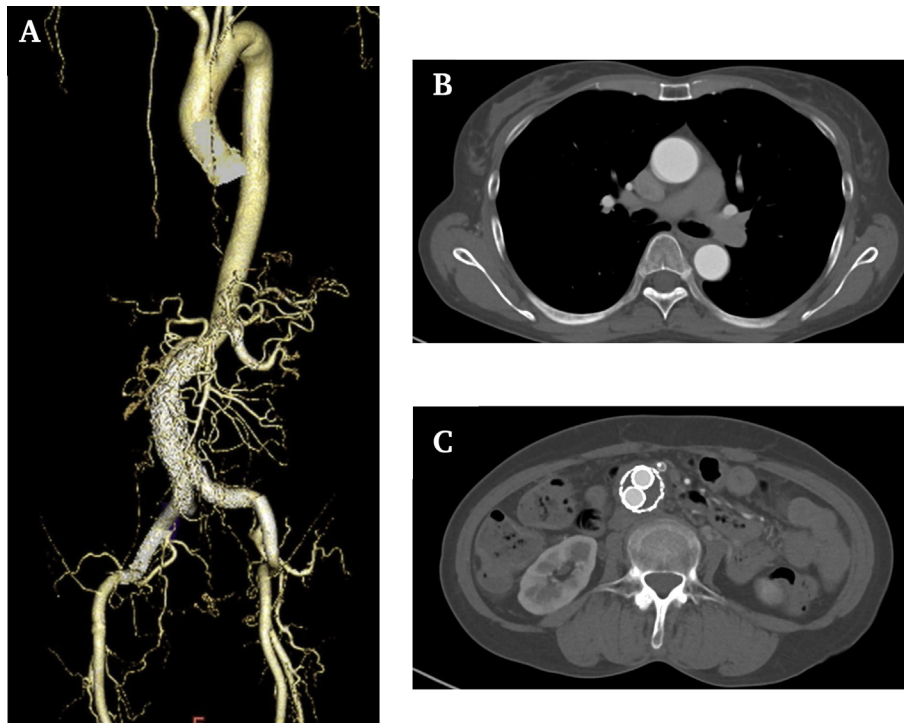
(A) Follow up computed tomography (CT) angiography three months post-operatively confirming patency of the left renal artery. (B) Enhanced CT confirming complete remodelling of the dissected false lumen of the descending aorta. (C) Enhanced CT confirming absence of endoleak and demonstrating complete thrombosis and shrinkage of the abdominal dissected aneurysm sac.
